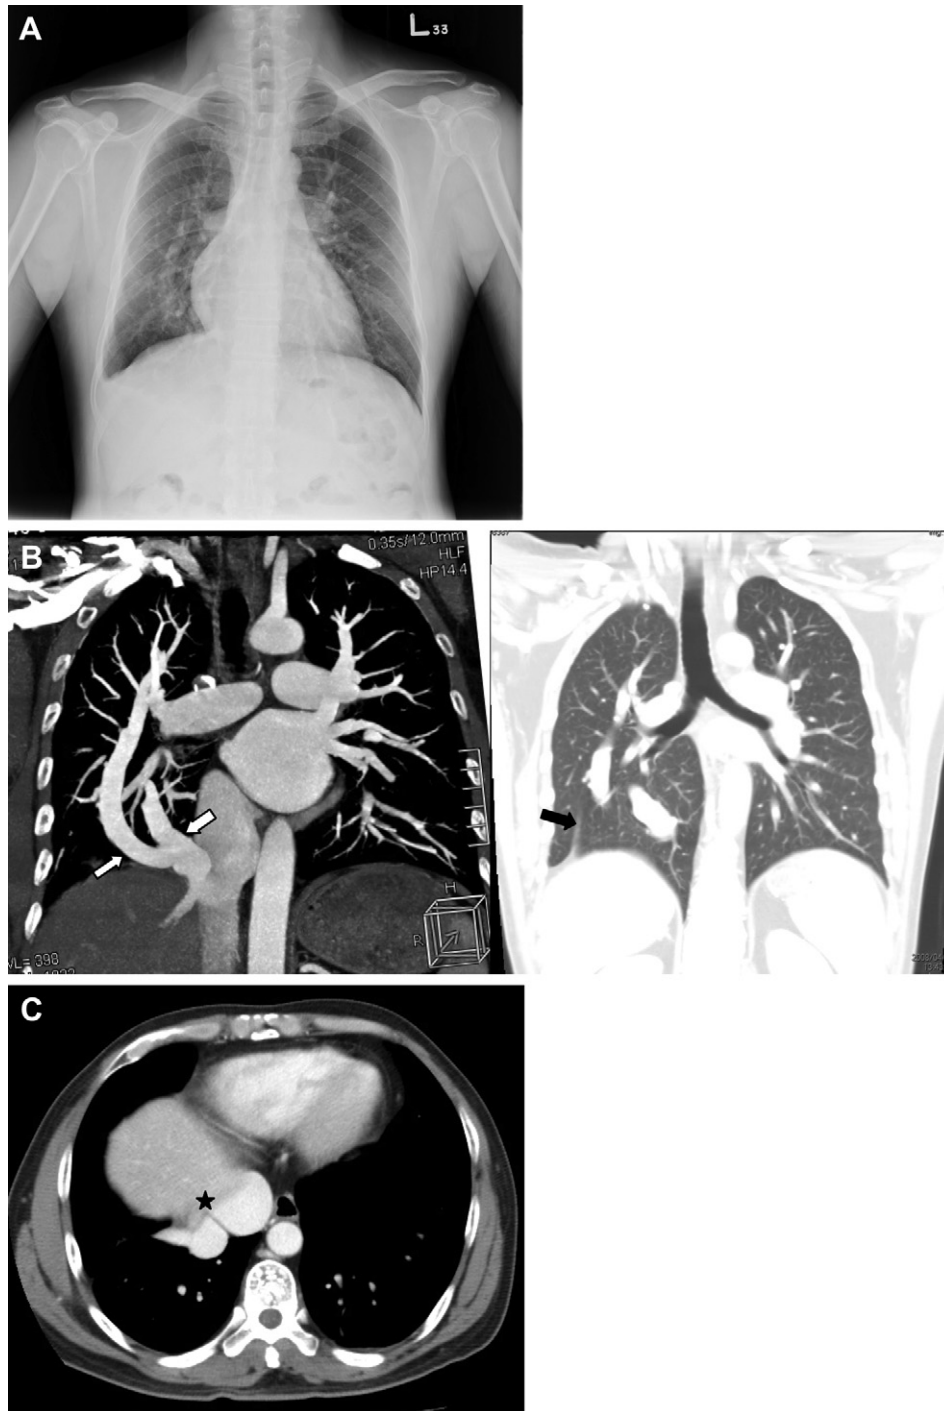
(A) Chest x-ray; (B) the double scimitar vein drained into the suprarenic inferior vena cava (IVC) with two convergent pulmonary veins (white arrow). Chest computed tomography (CT) coronal view with lung window showed an absence of right minor fissure and lack of right middle lobe. Only the right major fissure was observed (black arrow); (C) Chest CT cross-section where the scimitar vein joined the IVC, with a web-like material over the drainage site (black star).
